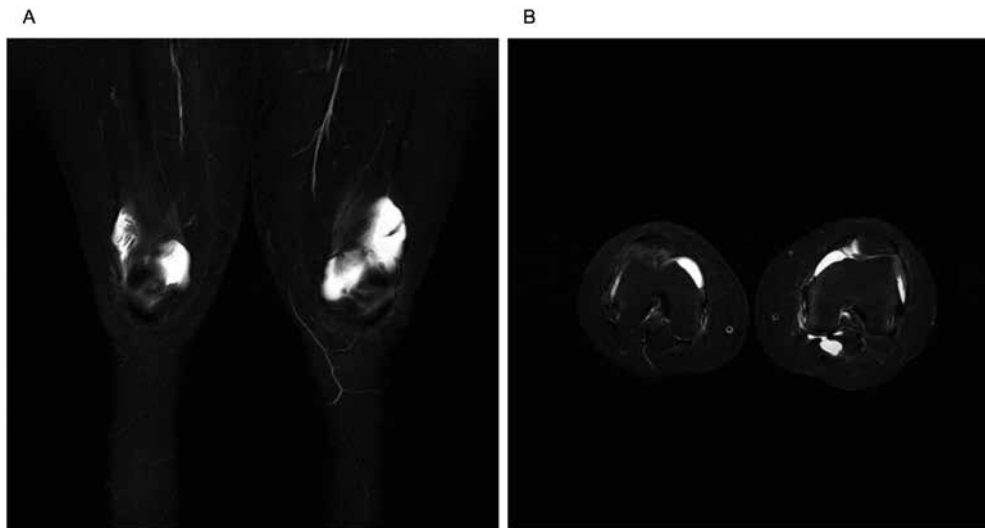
(A) MRI of both knees demonstrated chronic inflammation with synovial thickening. (B) MRI of left knee revealed Baker's cyst.
